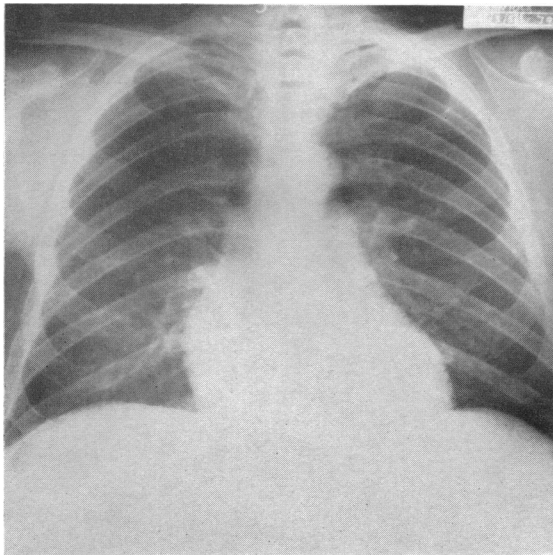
Six-foot postero-anterior radiograph of chest in Case 3, showing virtually normal cardiac silhouette.
